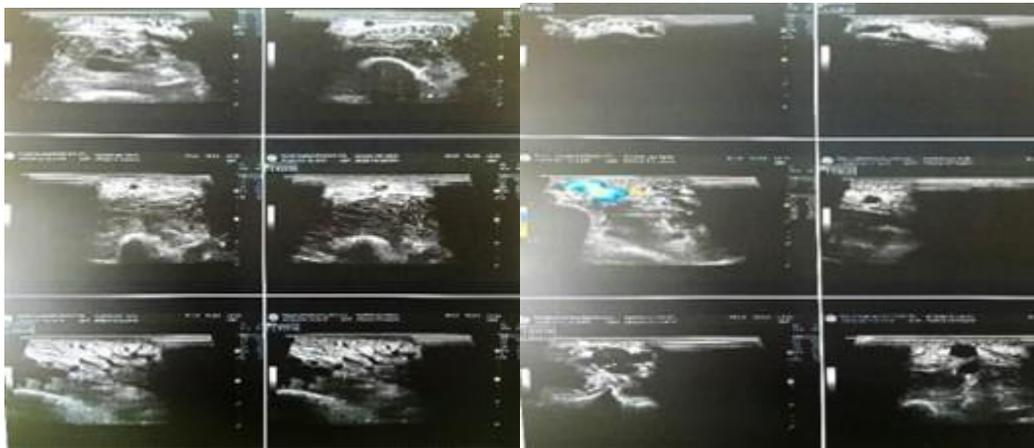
Postoperative Radiocephalic Avf Doppler Ultrasound
